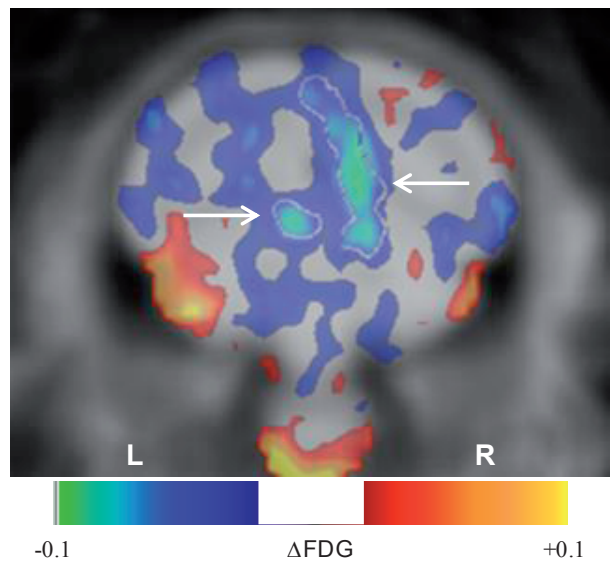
Glucose metabolism index decreases in medial occipital cortex in response to chronic 8-OH-DPAT treatment. The color scale indicates the mean difference in whole brain normalized radioactivity, $\Delta\text{FDG} = 8\text{-OH-DPAT}$ minus Saline. White contour marked by arrows delineates a significant negative 3D cluster in the corresponding t map, shown at Bregma -11.2 mm (2-tailed paired t test, $p_{\text{uncorrected}} < 0.05$, $\text{extent} = 60 \mu\text{L}$, $p_{\text{corrected}} = 0.004$). Mean difference arbitrarily thresholded at $0.02 < |\Delta\text{FDG}| < 0.10$.
